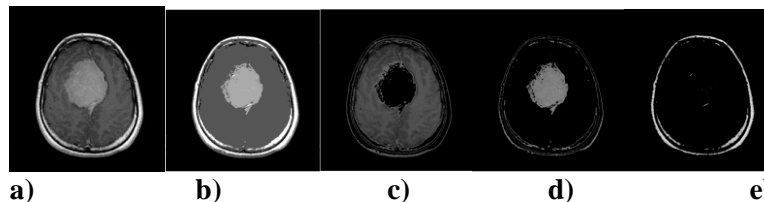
24 EM Segmentation algorithm applied on MRI slice.
